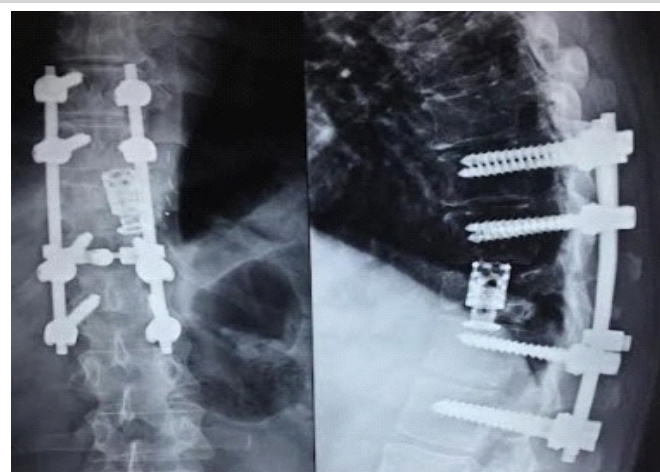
2-year follow-up X-ray showing well-positioned implants and no features of recurrence.
